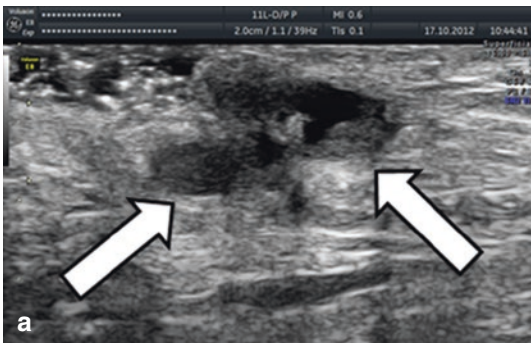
The ultrasonographic appearance of Villar's nodule (straight arrows) using B-mode (a) and color Doppler (b) in a 20-year-old woman without previous
